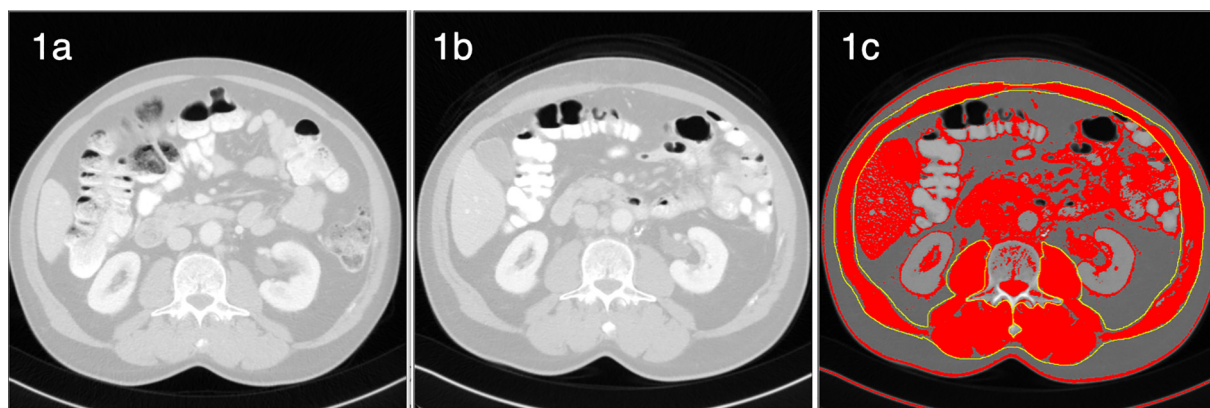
Muscle mass measurements on abdominal CT scans; 1a preoperative axial CT-image at the L3 level; 1b postoperative axial CT-image at the L3 level of the same patient; 1c measurement of cross-sectional area of skeletal muscle at the L3 level by applying Hounsfield unit thresholds of -29 to $+150$ and delineating skeletal muscle (between yellow lines).
